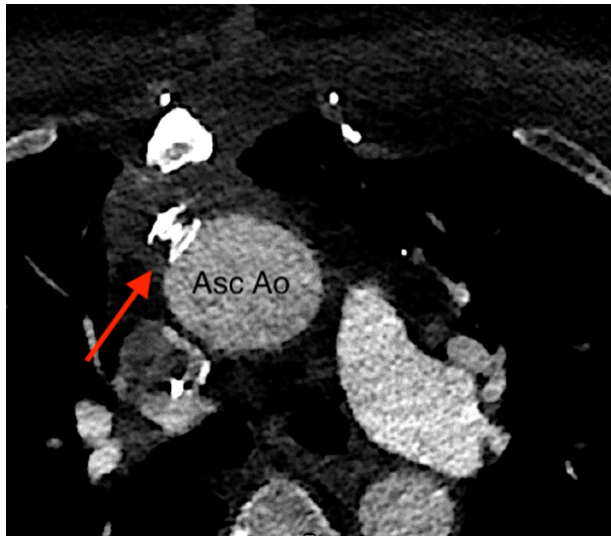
Follow-up chest CT with transverse view showing the device (*arrow*) in a well-seated position in the ascending aorta with a completely thrombosed cavity. Asc Ao, Ascending aorta.
